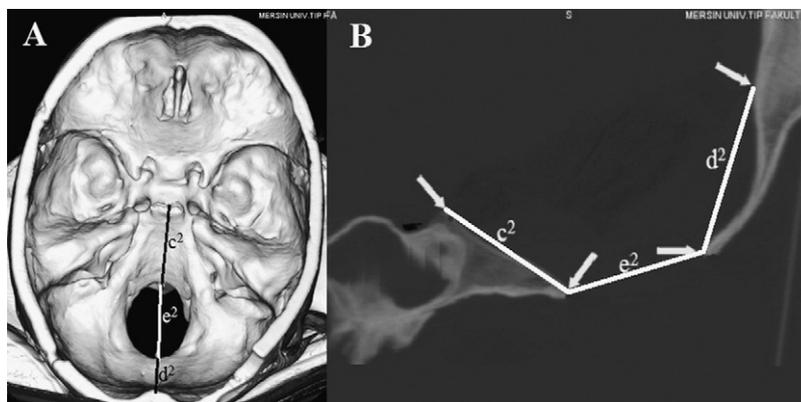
Parameters were measured on CT for the 30 dry skulls. (A) Three-dimensional reconstruction CT scan c^2 : length of the clivus, d^2 : length of the supraocciput, e^2 : the anteroposterior diameter of the foramen magnum; (B): sagittal CT scan showing c^2 , d^2 , and e^2 .
